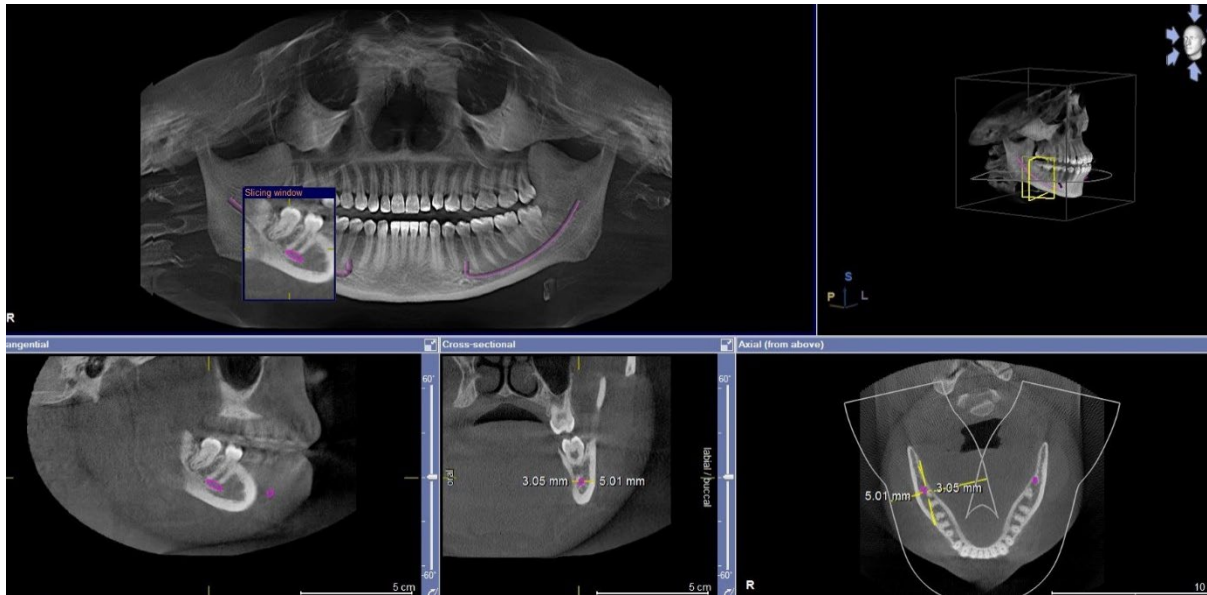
Overall views of CBCT images
